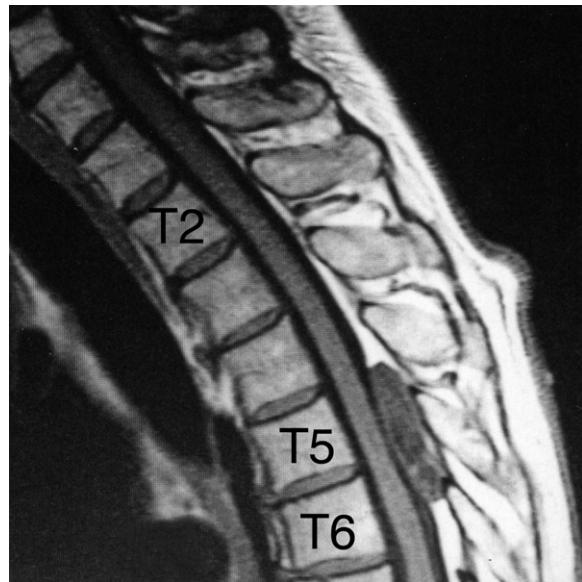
Thoracic spine MRI sagittal T1-weighted image showing the T5–6 level ovoid lesion measuring 3.7 cm in length × 0.9 cm in its anteroposterior diameter involving the posterior epidural space.
